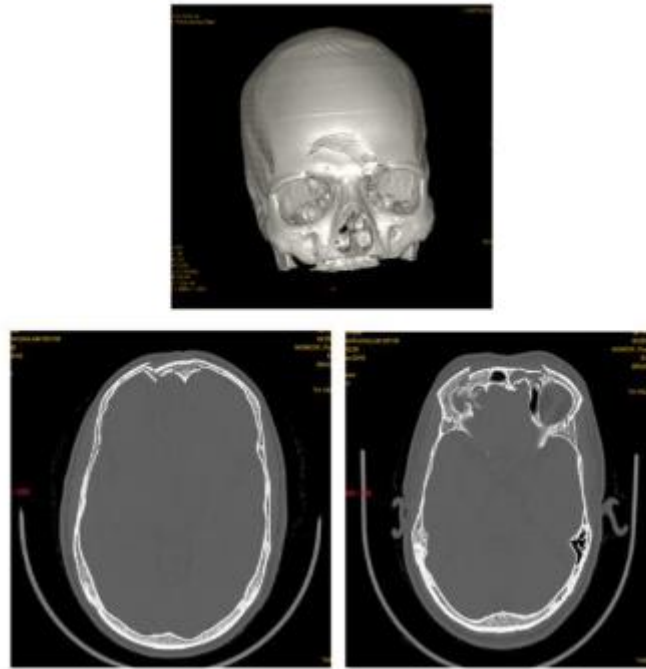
Sequence of images A-C [3D-CT (a), Axial images Shows comminuted depressed fracture in the frontal bone with hemisinus
